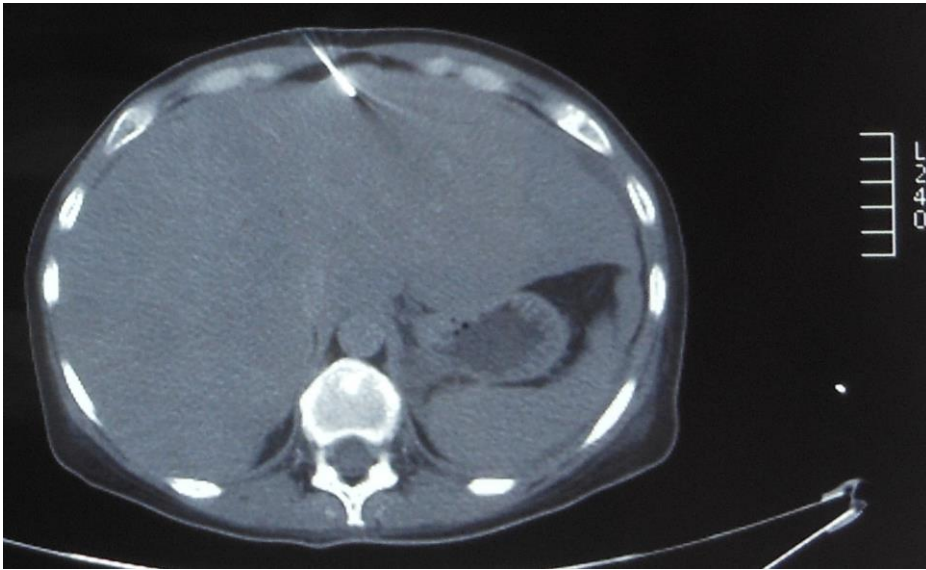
A CT scan-guided fine-needle and core-needle biopsy needle is on target on the tumor.
